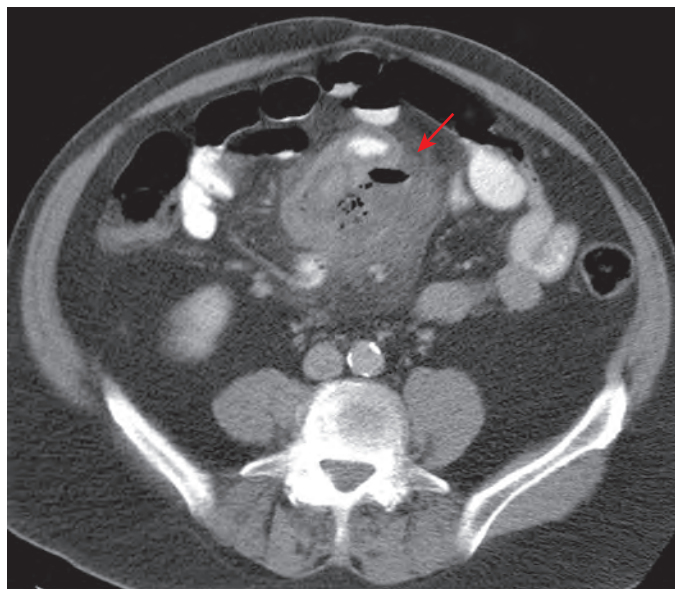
Meckel's diverticulitis: CT features. Axial CT image shows a gas-containing abscess (arrow) and inflammatory change in the ileocolic mesentery.
